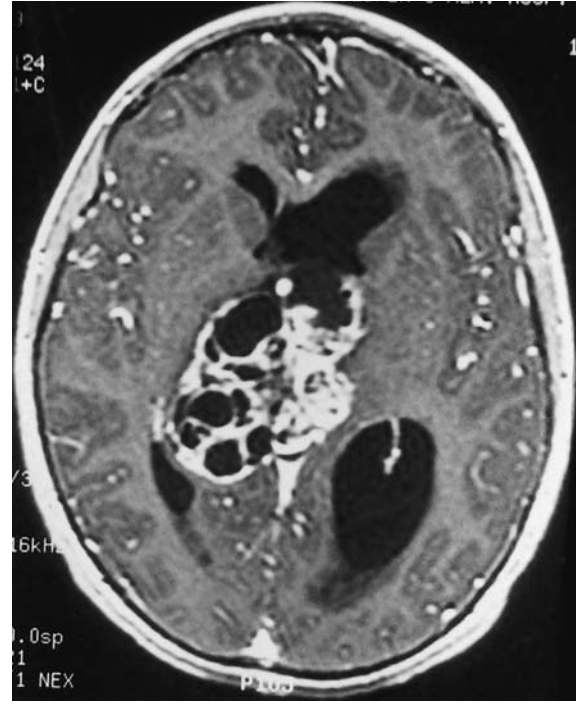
Axial MRI after contrast infusion (same case as Fig. 12–15) showing a heterogeneously enhancing teratoma. Note that the tumor extends further laterally into the lateral ventricle.
